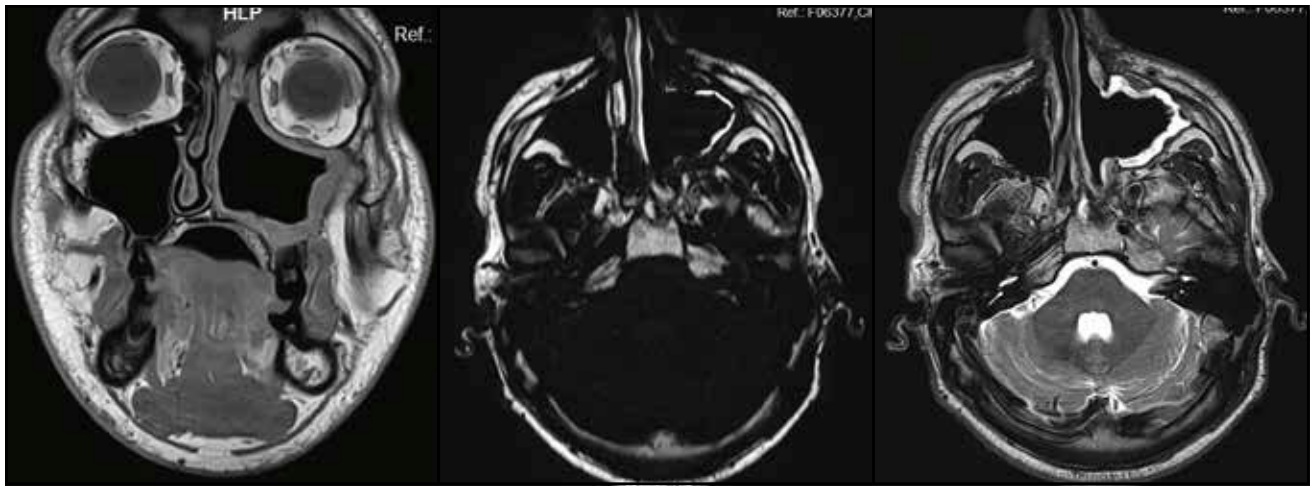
Nine months postoperative contrast enhanced MRI (T1 and T2 signal coronal and axial sections) showing nasal cavity and maxillary sinus with no presence of tumor.
